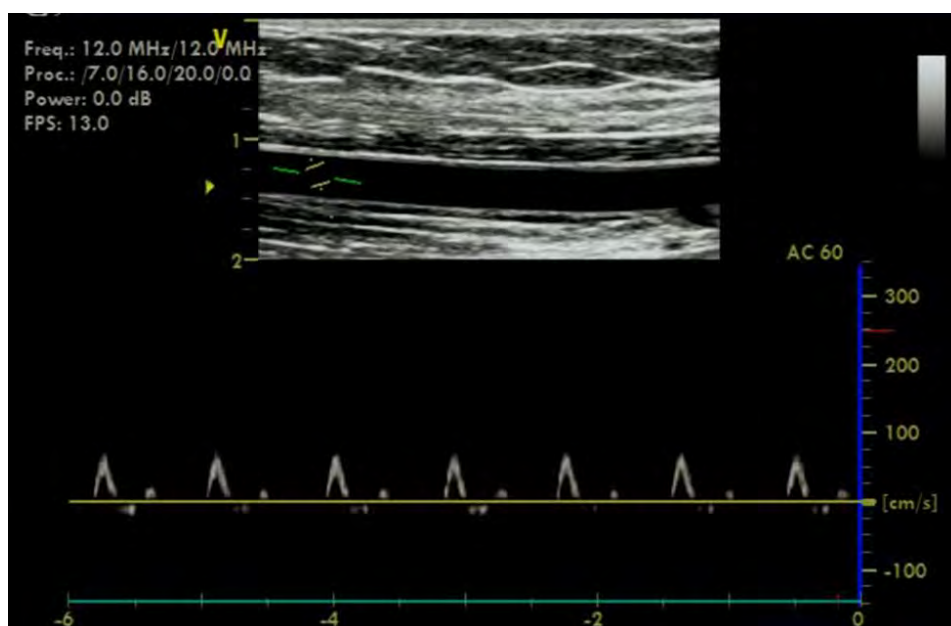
Example of a duplex ultrasound image. The right brachial artery was imaged using duplex ultrasonography to determine simultaneous recordings of arterial diameter and blood (Doppler) velocity.
